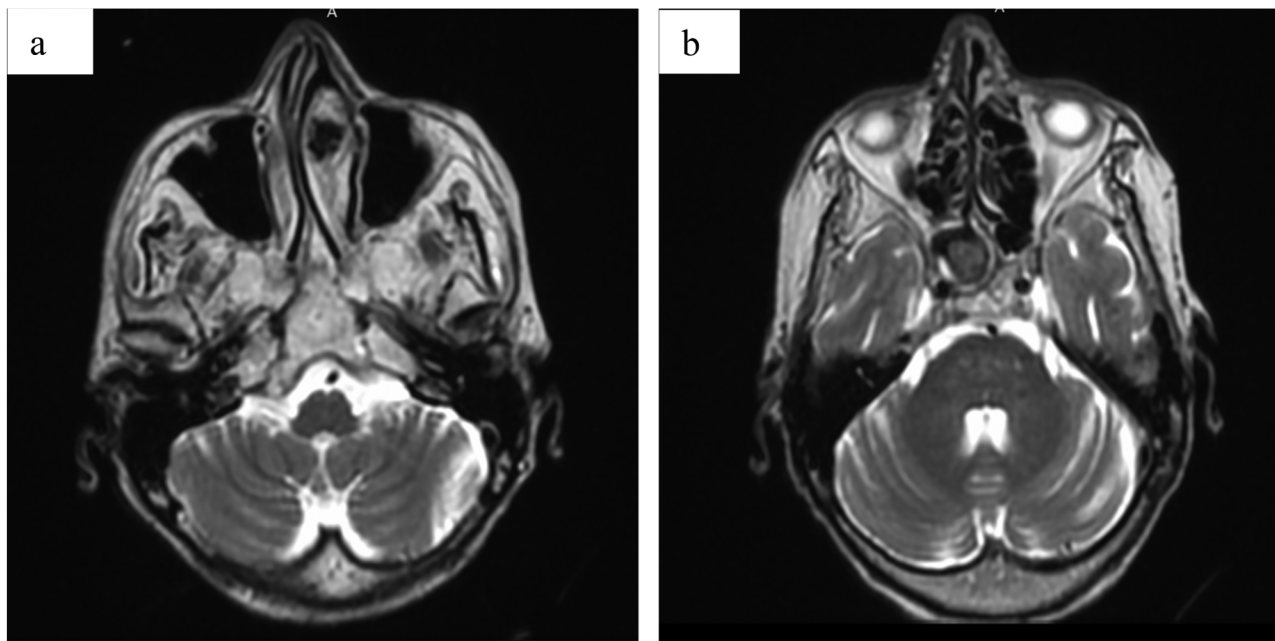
Paranasal magnetic resonance imaging (MRI): (a) left concha bullosa filled with a material heterogeneous signal T2 with a central void signal related to a fungal ball and (b) nonspecific right chronic sphenoidal sinusitis.
